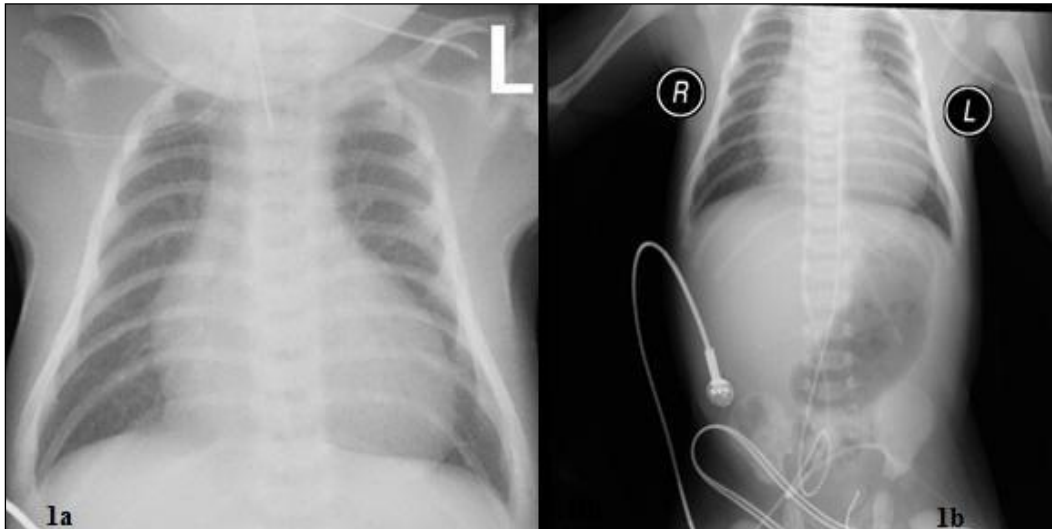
AND 1b: X-RAY CHEST AND ABDOMEN AT DAY 3 DEPICTING CARDIOMEGALY. NO PERIOSTEAL REACTION ALONG THE RIBS, CLAVICLES OR HUMERII
